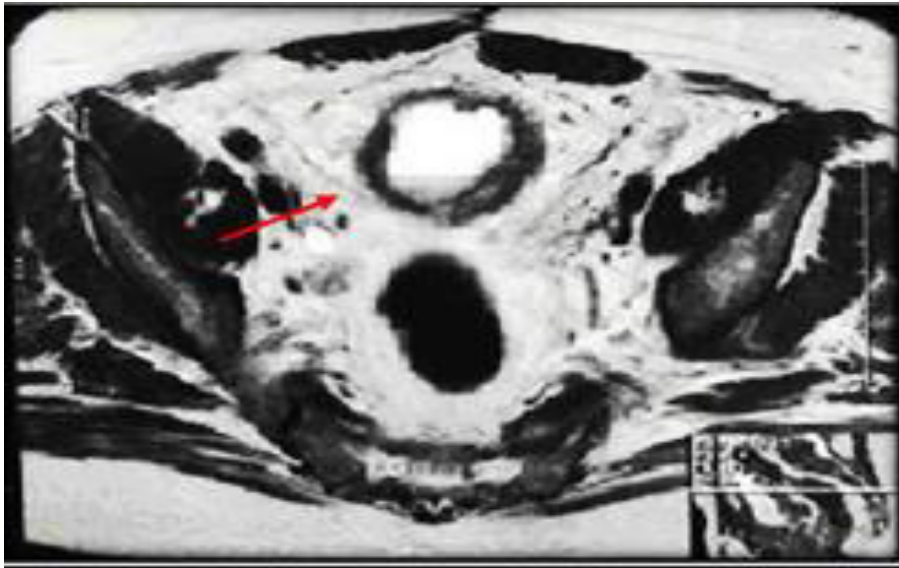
Magnetic resonance imaging showing urinary bladder wall thickening associated with an exophytic lesion.
